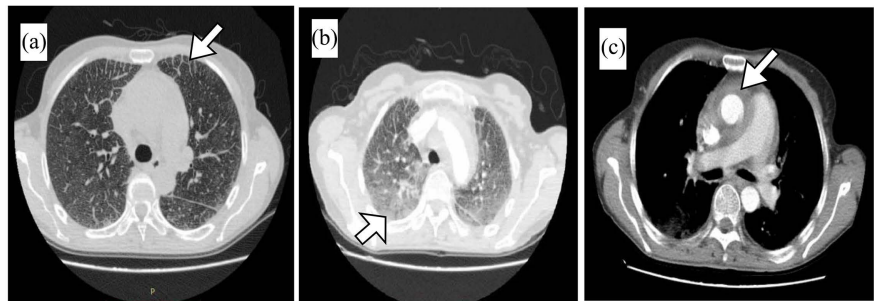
Chest CT showing (Arrows): (a)—Thickening of interlobular septa; (b)—Diffuse ground glass, predominantly in basal portions bilaterally; (c)—Mediastinal thickening with coating of the thoracic aorta (Coated Aorta).
